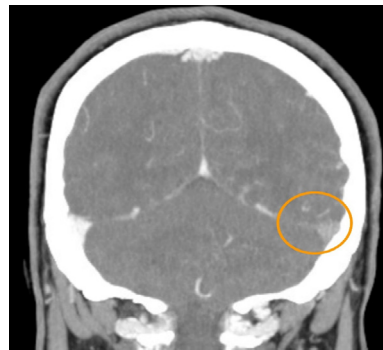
CT venogram with contrast head showing asymmetric filling defect in left transverse sinus (orange circle).
